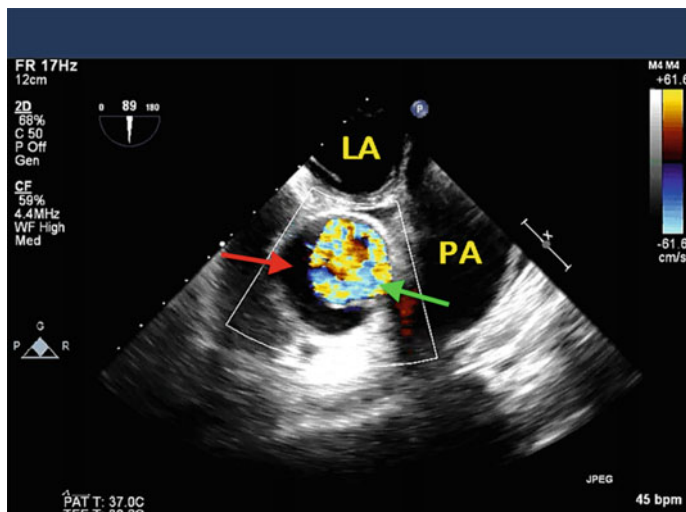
Midesophageal view of ascending aorta developed by a slow withdrawal of the probe from an aortic valve short axis. The *green arrow* points to a true lumen with noted rapid early systolic flow while the *red arrow* indicates the false lumen with little to no flow demonstrated on color flow Doppler (LA left atrium; PA main pulmonary artery)
